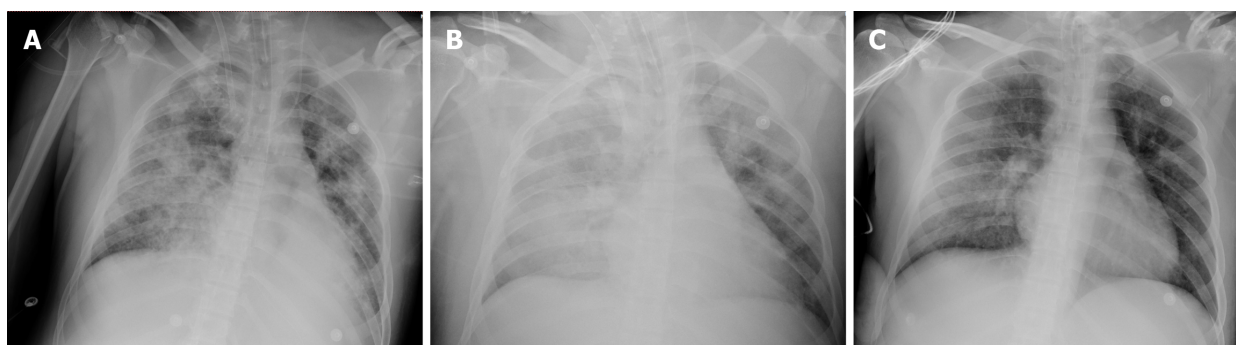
Changes in bedside chest X-ray. A: The bedside chest X-ray after intubation showed diffuse infiltration in both sides of the lung; B: The bedside chest X-ray on day 3 after admission to the intensive care unit revealed persistent, severe diffuse infiltration of both the lungs; C: The bedside chest X-ray on the day before the termination of extracorporeal membrane oxygenation showed significantly decreased lung infiltration.
